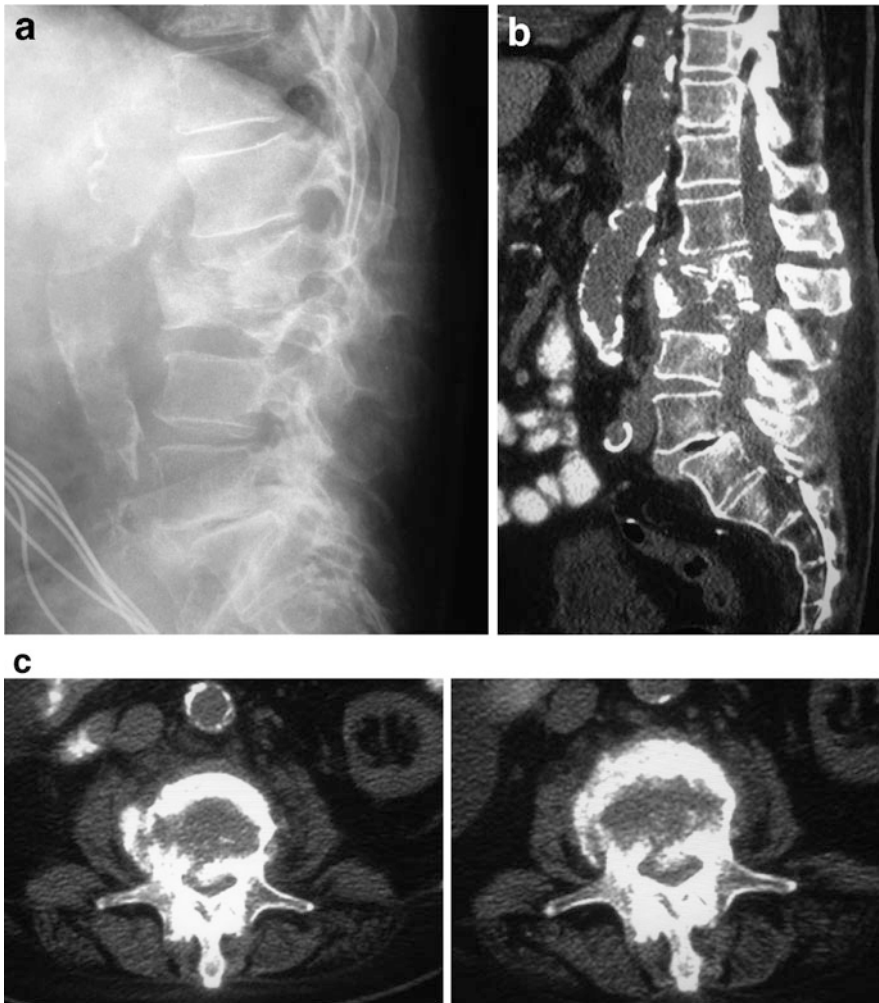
Sagittal fluoroscopic (a) and sagittal (b) and axial (c) computed tomography images of a burst fracture. There is retropulsion of fracture fragments into the spinal canal
